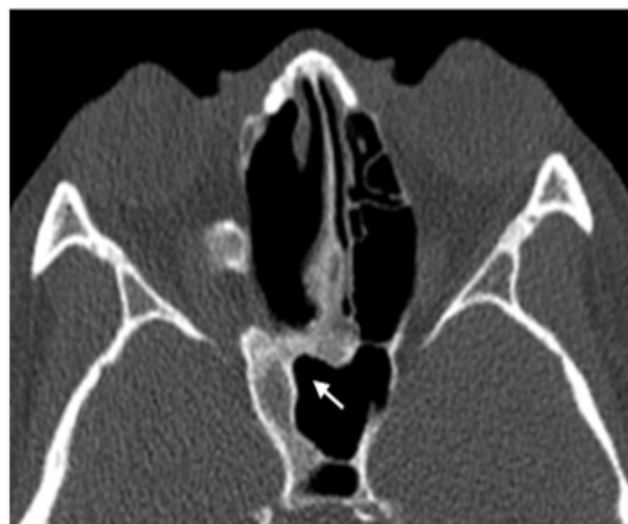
Bone window sinus CT scan/axial cut: persistence of some residual tumor on the skull base (arrows).
